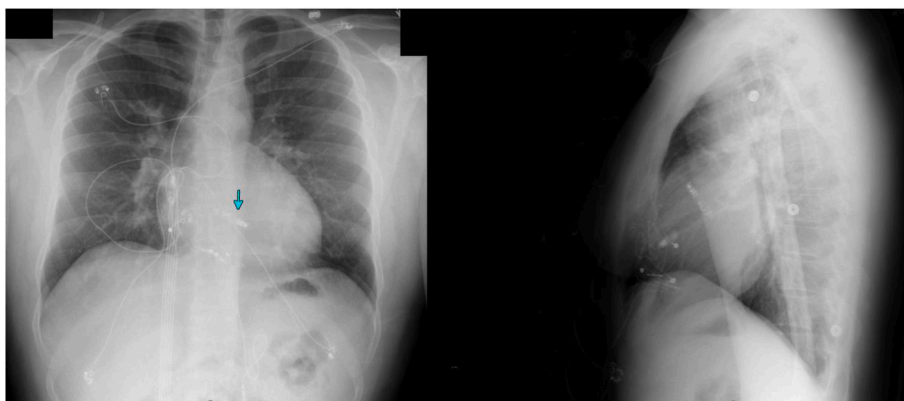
2-view chest Xray after lead extraction and dual leadless pacemaker implant.
